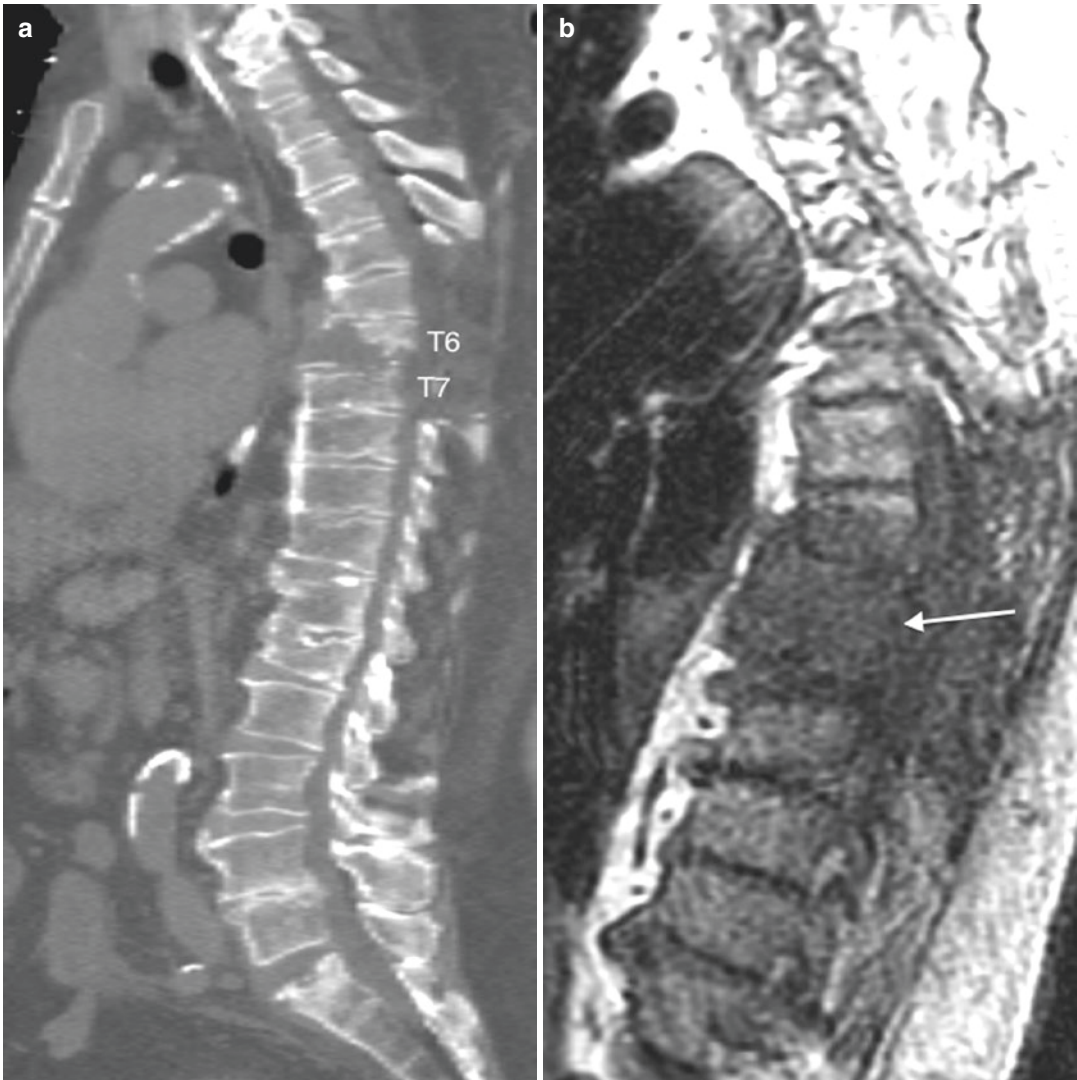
A 65-year-old male with methicillin-resistant *Staphylococcus aureus* (MRSA) proven T6-T7 septic spondylodiskitis. Reformatted sagittal CT image in bone window algorithm (a) shows irregularity of the T6 and T7 endplates with advanced erosion and destruction of the T6 vertebral body. Sagittal T1-weighted image (b) shows diffuse hypointense signal (arrow) from T6 to T7 with loss of the normal endplate cortical margins. Sagittal T2-weighted image (c) shows hyperintense fluid signal
